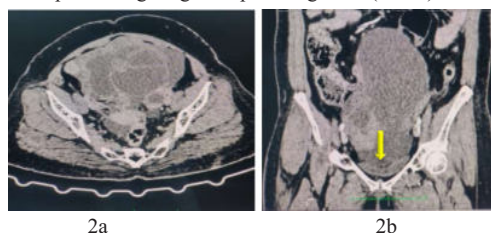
A 51-year-old female with complaints of abdominal pain, distension since 3 months with increased frequency of micturition since 20 days. Contrast enhanced CT imaging of abdomen and pelvis showed large solid cystic lesion with thick enhancing wall and thin internal septations (2a-axial section) and mass effect over the bladder (arrow) (2b-coronal section)
